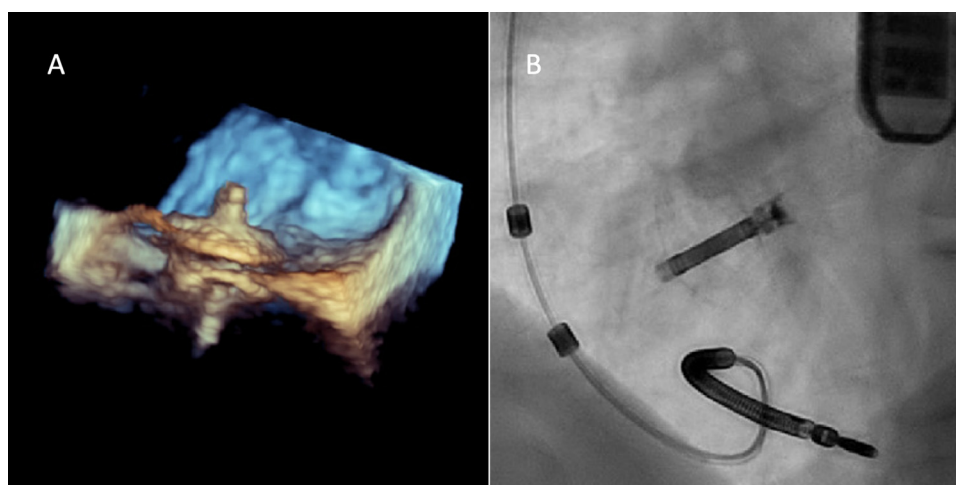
A, Transesophageal echocardiography; B, fluoroscopy of the V-LAP following implantation at the interatrial septum.
